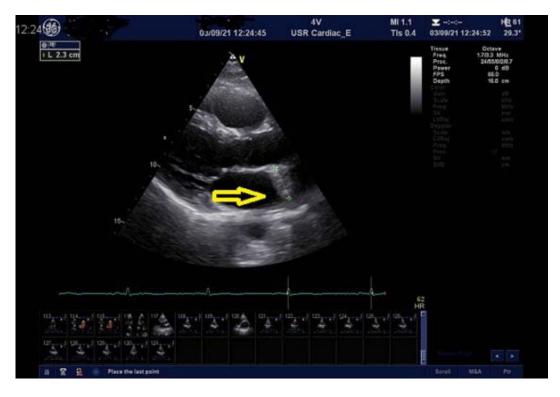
Echodense shadow at the posterior aspect of the left atrium on the parasternal long-axis view (arrow).
